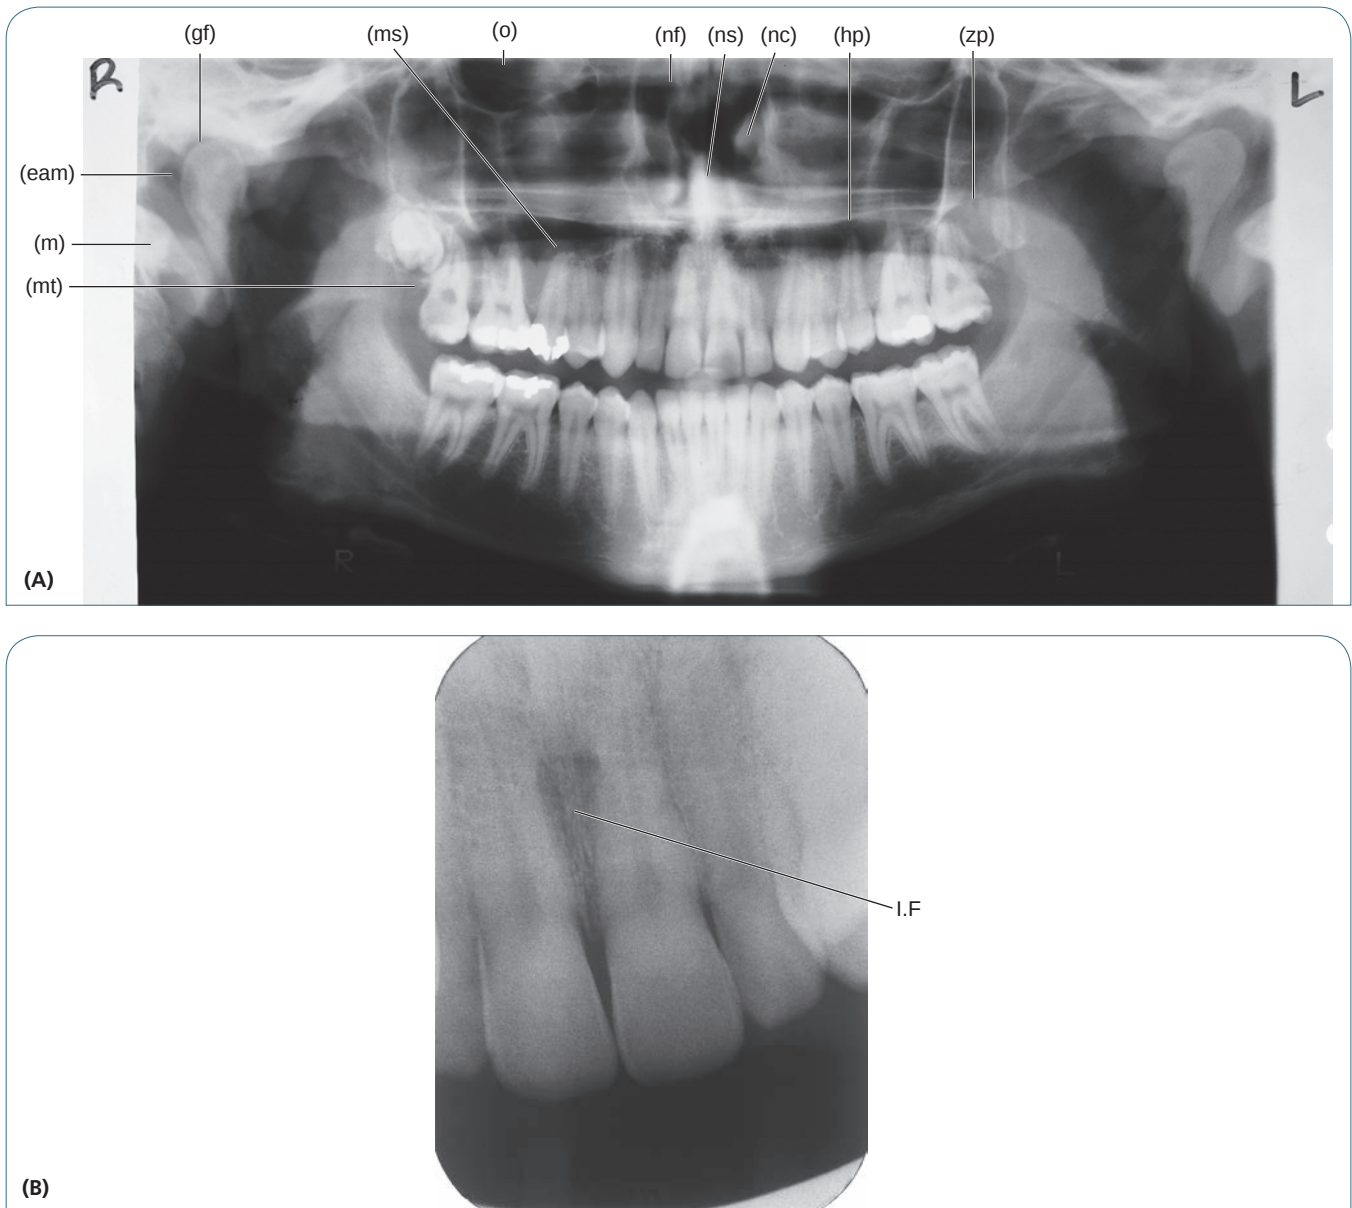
(A) Panoramic and periapical radiograph identifying the maxillary landmarks: (mt) Maxillary tuberosity, (m) Mastoid process, (eam) External auditory meatus, (gf) Glenoid fossa, (ms) Maxillary sinuses, (o) Orbit, (nf) Nasal fossa, (ns) Nasal septum, (nc) Nasal conchae, (hp) Hard palate, (zp) Zygomatic process. (Courtesy of Dr. Rodney Braun and Dr. Chris Chaffin.) (B) (if) Incisive foramen.
